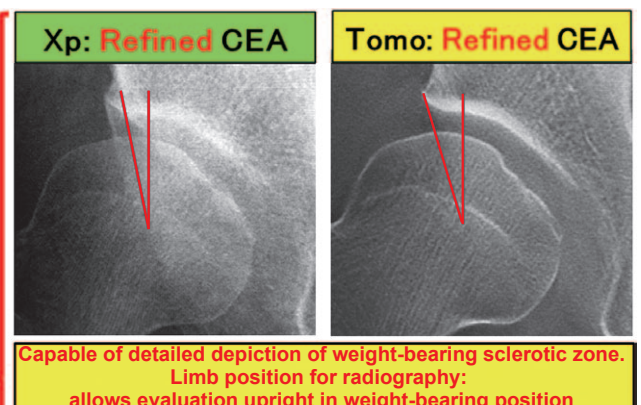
Comparison of this Study and a Previous Report on Radiography Methods for Diagnostic Imaging of Acetabular Dysplasia^{2),6)}
